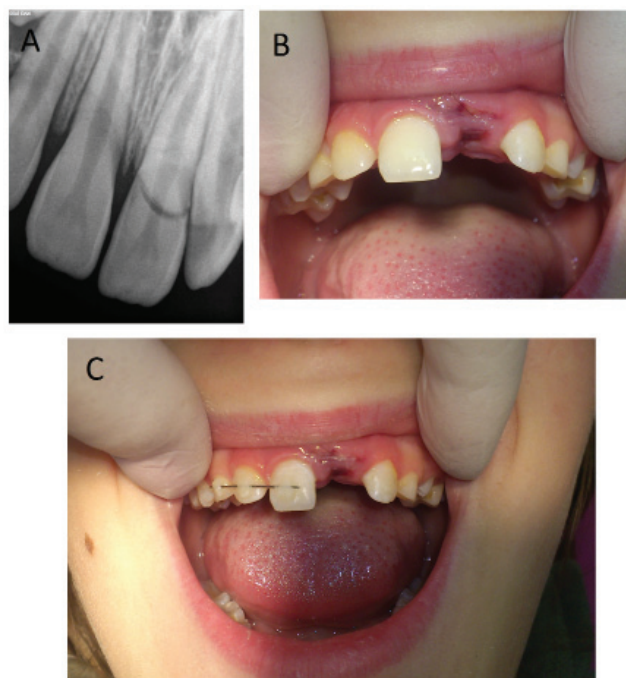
A – dental radiograph taken at the day of trauma. Tooth #21 is horizontally fractured at the cervical area. Periapical region of the tooth #21 cannot be assessed. B – missing clinical crown and the dental socket of the tooth #21 filled with a blood clot – clinical situation during the first appointment. C – semi-rigid splint connecting the teeth #11–#13 applied due to the subluxation of the tooth #11
